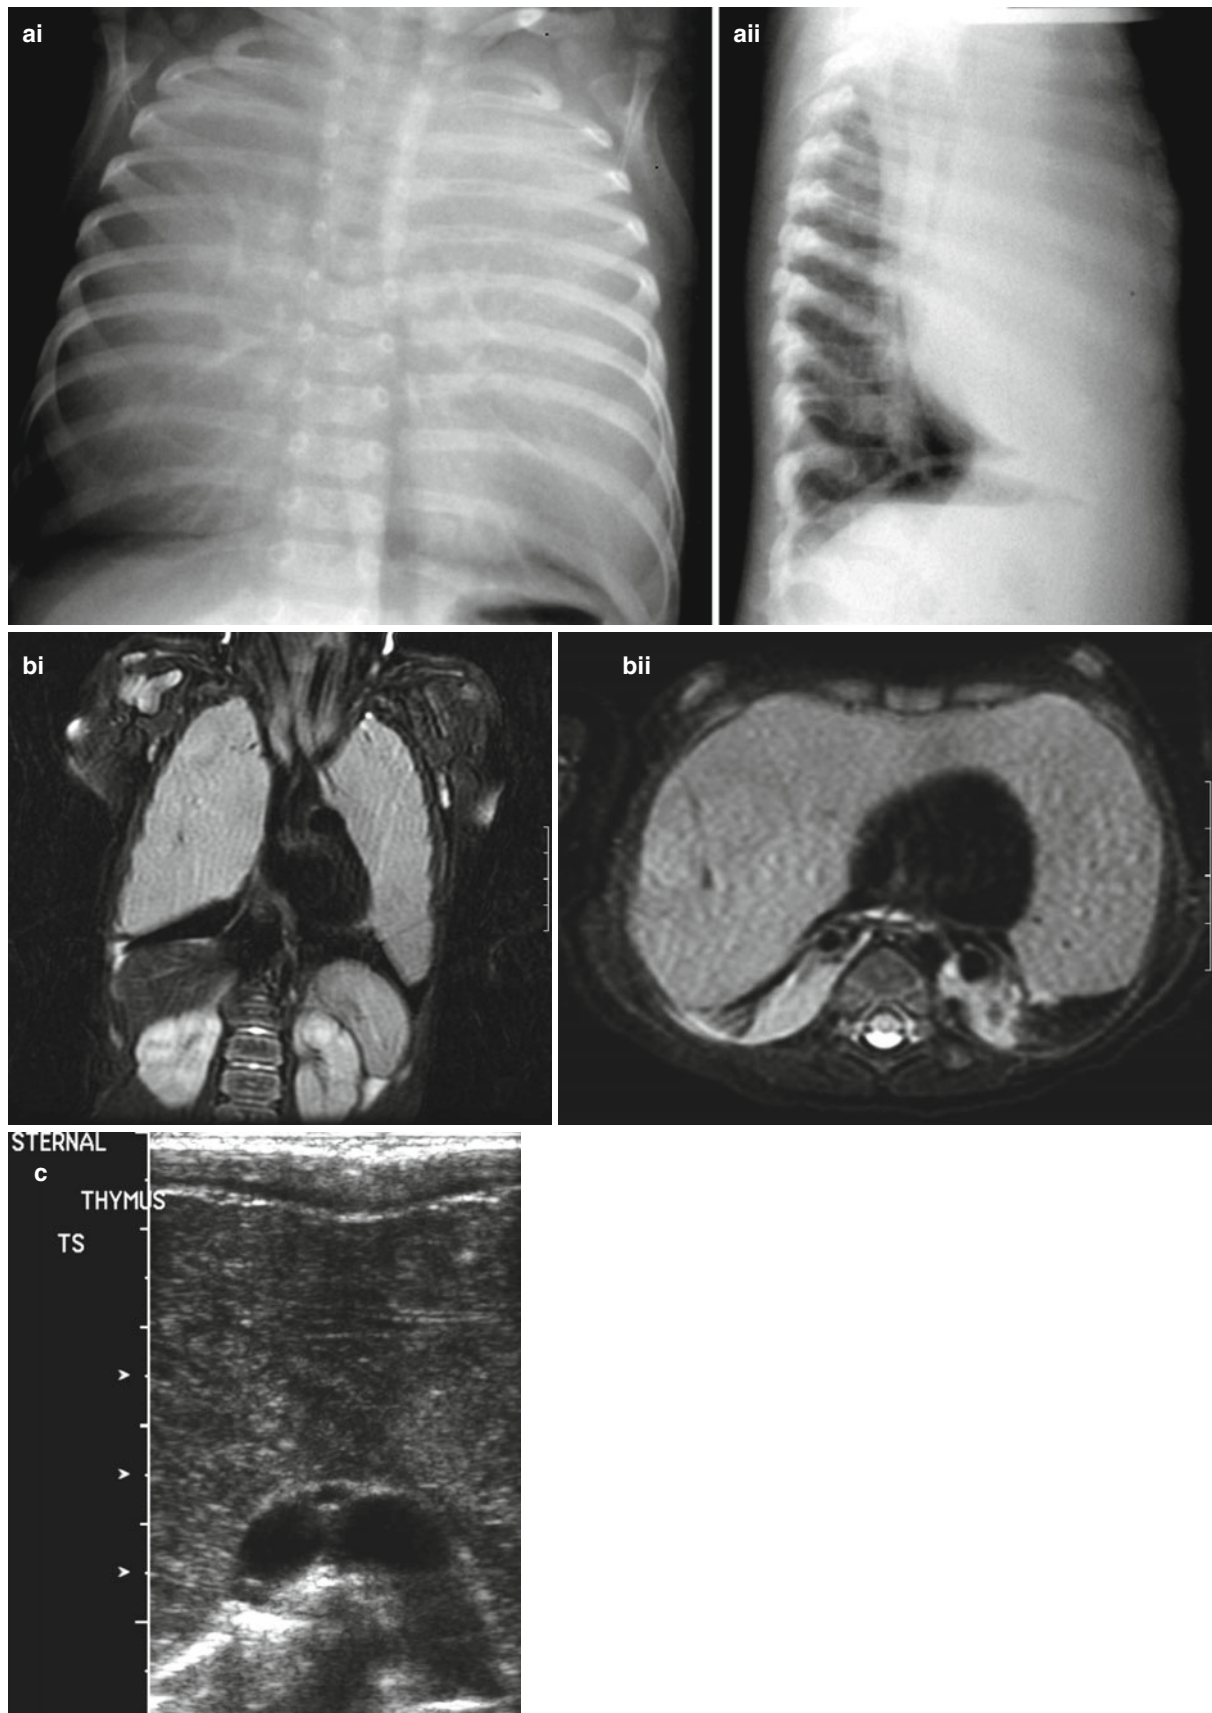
Massive thymus in a neonate. (a) AP (i) and lateral (ii) chest radiographs show that the thymus occupies nearly all of the thoracic cavity. (b) The thymus is confirmed on MR (i) coronal and (ii) axial
